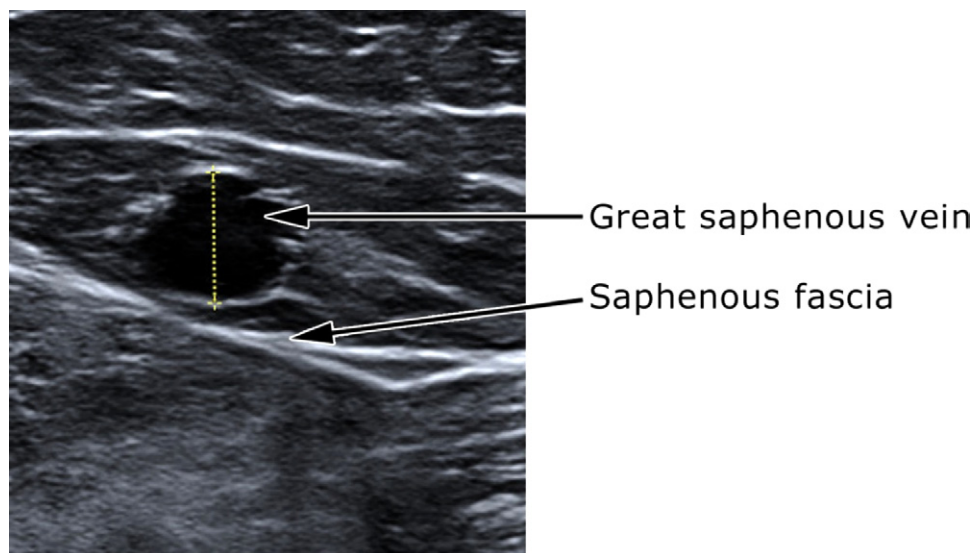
Ultrasound-based definition of saphenous vein. Saphenous veins (such as the great saphenous vein [GSV]) are enclosed above and below the vein in a fascia, visible on cross-sectional ultrasound as an “Egyptian eye” (white lines above and below the GSV), which “blinks” (compresses) with probe pressure. This definition is important due to hemodynamic differences between saphenous and epifascial veins. Photographed by Terry Williams, RVT, and Eric Mowatt-Larssen, MD and adapted from Mowatt-Larssen E, Shortell C, Desai S: Clinical Review of Phlebology and Venous Ultrasound. Durham, NC, Surgisphere Corporation, 2012,³⁸ with permission.
